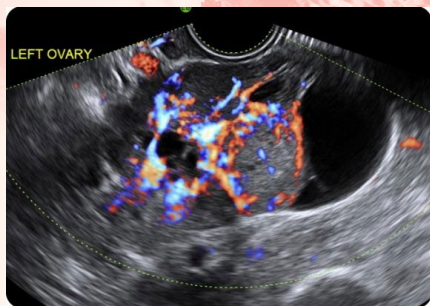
Transvaginal US of an LGSC appearing as complex ovarian tumour with abundant colour flow on Doppler imaging.
